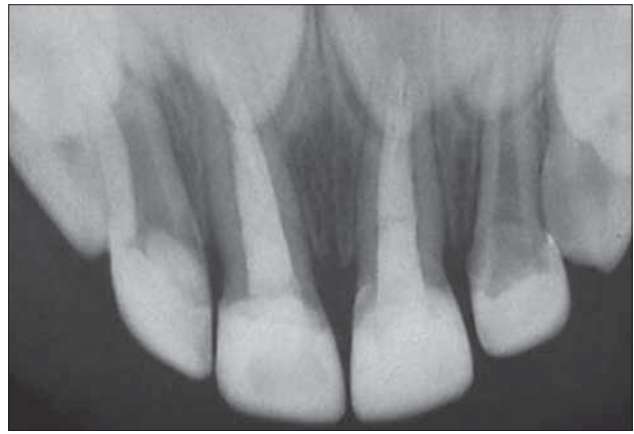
Immediate postoperative radiograph of the same patient's pulpctomized central incisors.
